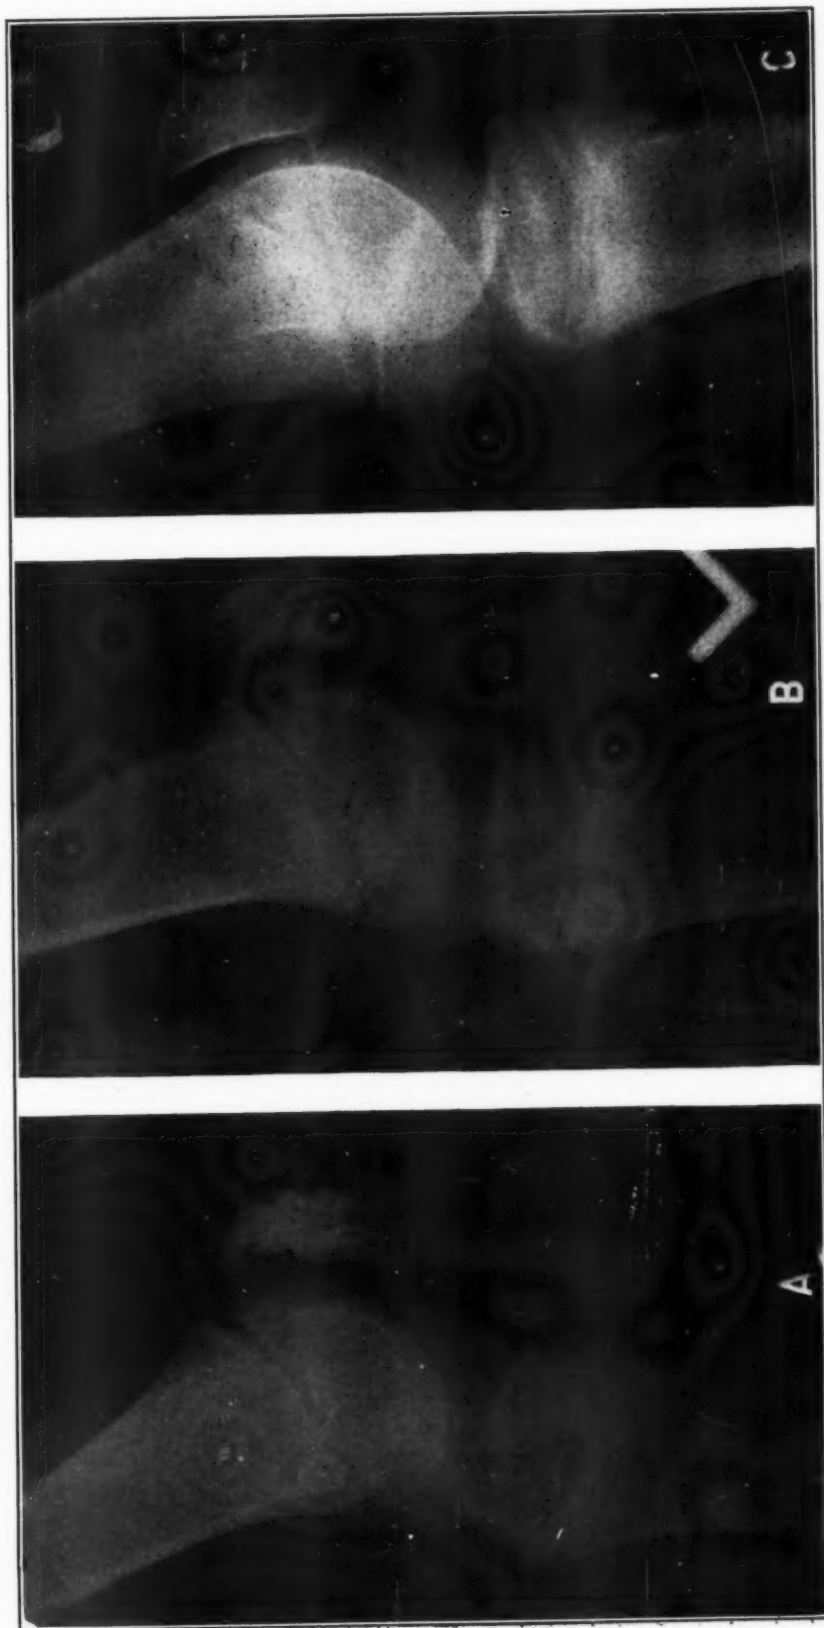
Roentgenographic register of change in bony texture of patella under appropriate therapeutics (Zuck²⁰). SS 2895, male, white, chronological age A 15 years 4½ months; B 16 years; C 16 years 6½ months.
